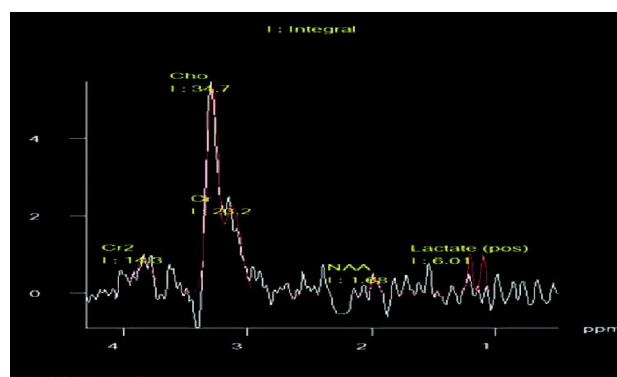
A well defined heterogenous enhancing extraxial mass lesion in the CP angle cistern with widening of the internal auditory meatus appearing predominantly iso on T1, hyper on T2 & FLAIR with both solid & cystic components s/o acoustic schwannoma. MRS shows raise in Cho peak and mild raise in lactatate with NAA in the base line. No e/o alanine peak thus differentiating it from meningioma.
